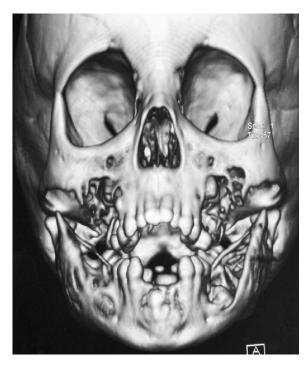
3D reconstruction radiograph revealed multiple radiolucent expansile lesions involving ramus, part of body of mandible, maxillary sinus
